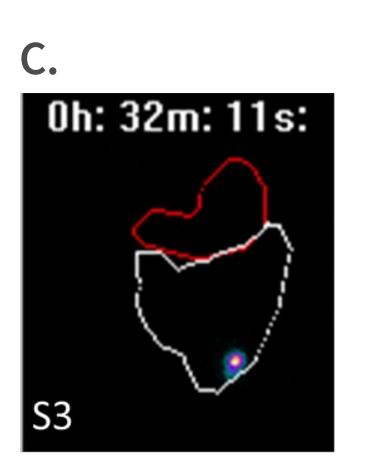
Gamma scintigraphy images of "In-DTPA in the DDS device and regions of interest in different GI segments with water containing
